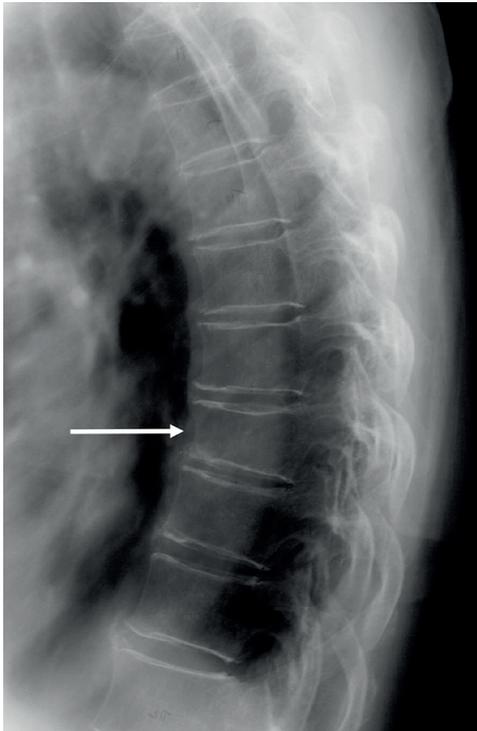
Lateral thoracic spine radiograph demonstrating an example of a developmentally short vertebra (arrow). This vertebra was unchanged for 15 years and the patient had no other evidence of disease. Therefore it was presumed to be a developmentally short vertebra.
